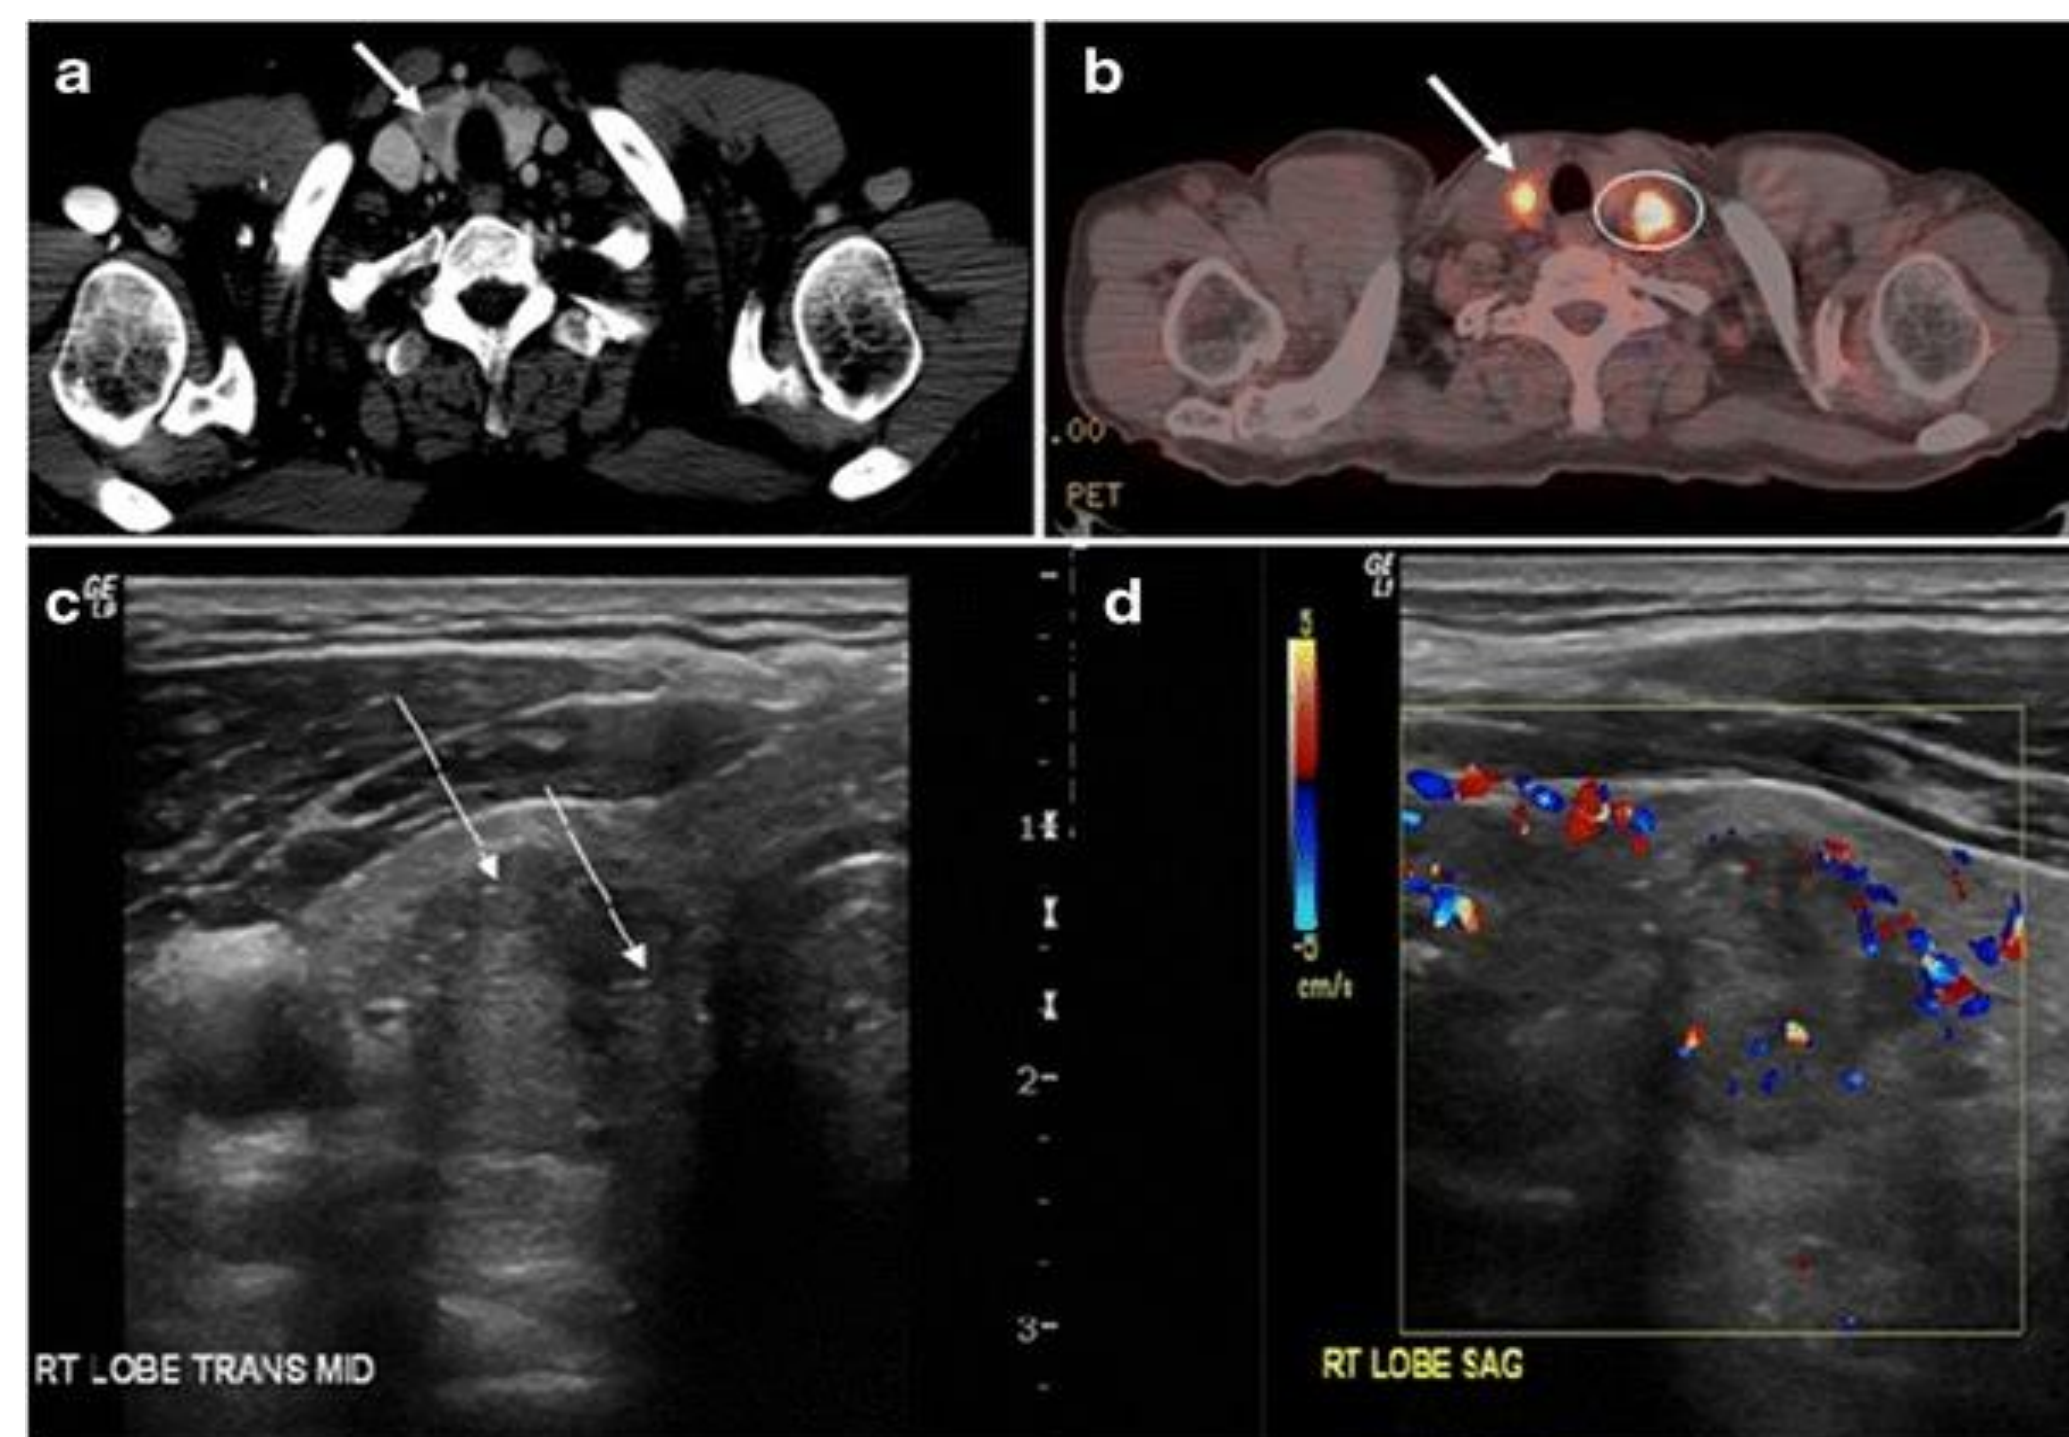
Papillary Thyroid Carcinoma on CT, PET CT and Ultrasonography. Photo courtesy of Mnahi Bin Saeedan, et al. Wikimedia. [https://commons.wikimedia.org/wiki/File:Papillary\\_thyroid\\_carcinoma\\_on\\_CT,\\_PET\\_CT\\_and\\_ultrasonography.jpg](https://commons.wikimedia.org/wiki/File:Papillary_thyroid_carcinoma_on_CT,_PET_CT_and_ultrasonography.jpg)
